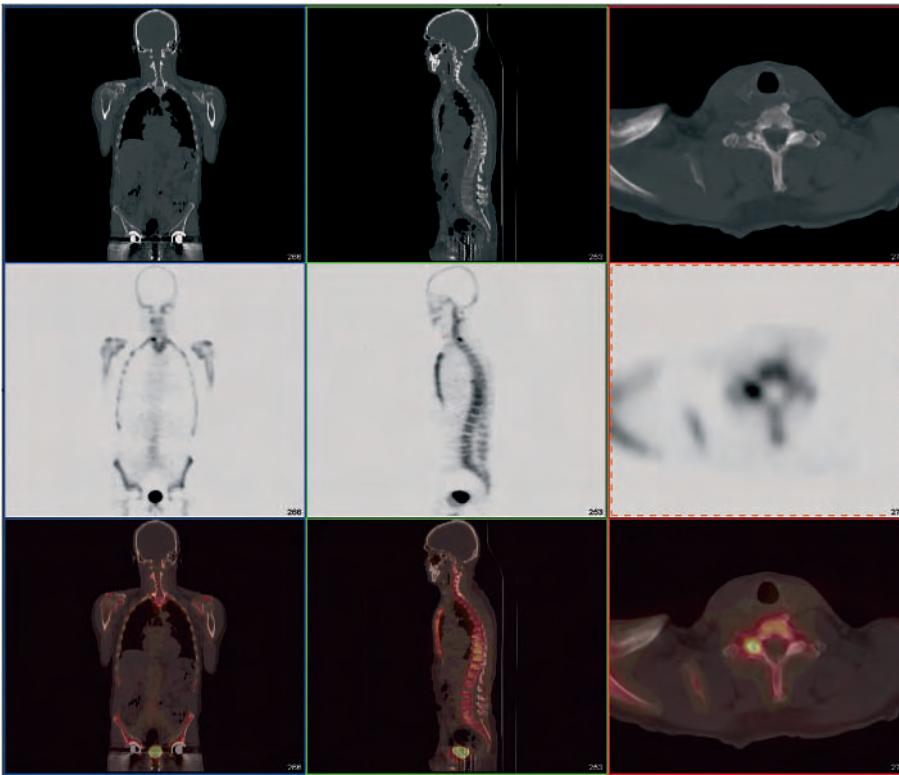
PET/CT scan using ^{18}F -fluoride and no contrast in a 67-year-old man with treated prostate cancer and a normal serum PSA level. *Left panel*, coronal cuts; *middle panel*, sagittal; and *right panel*, axial images. *Top row*, CT in bone window; *middle row*, PET; and *bottom row*, the fused image with CT in gray scale and PET in color. Note the increased uptake in the right C3 facet joint. The CT shows only degenerative changes, where the hot spot is localized (fused image)
